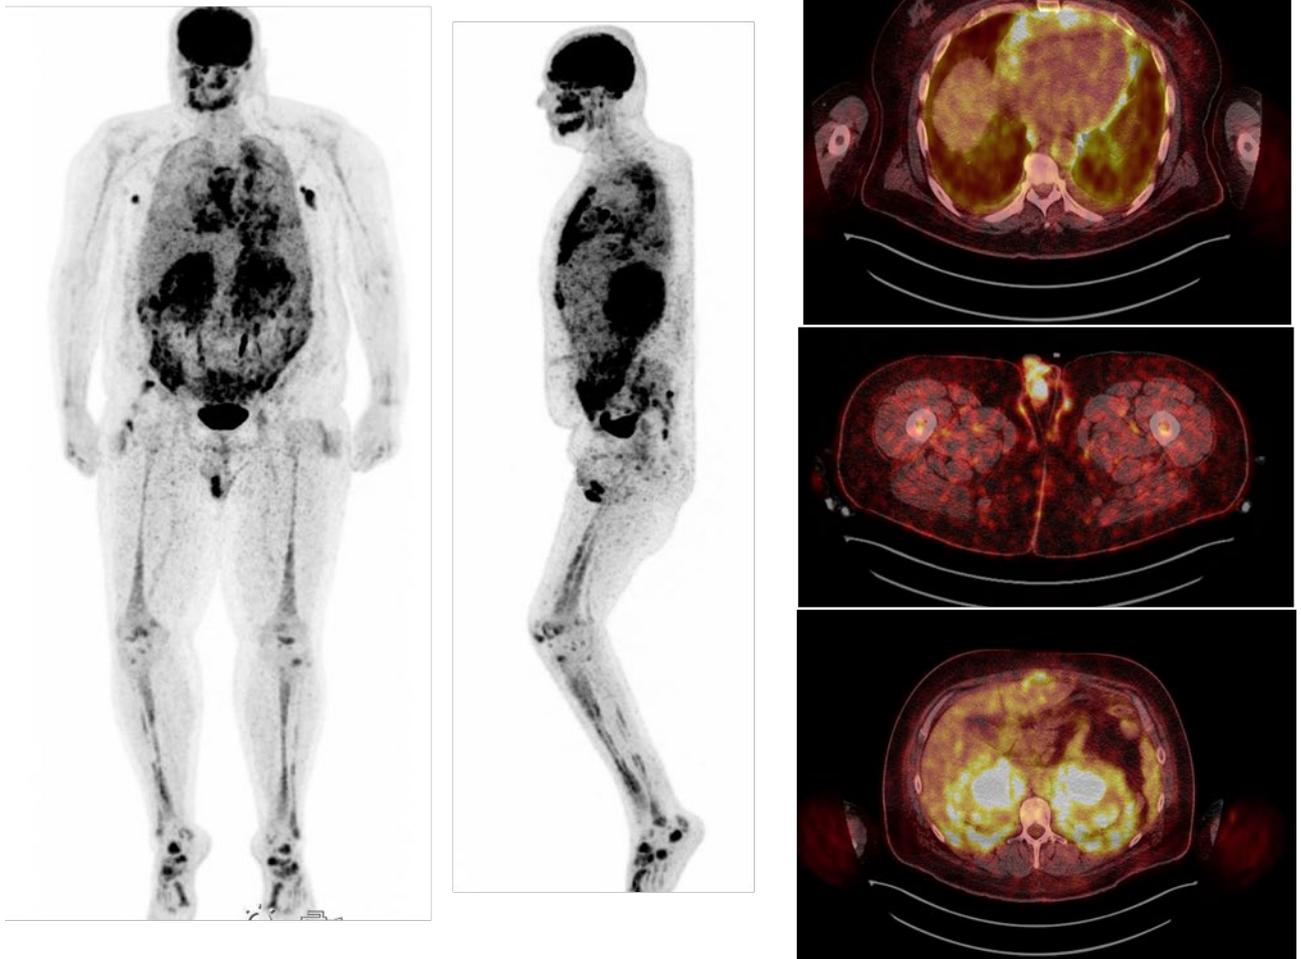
Initial ^{18}F FDG PET CT
